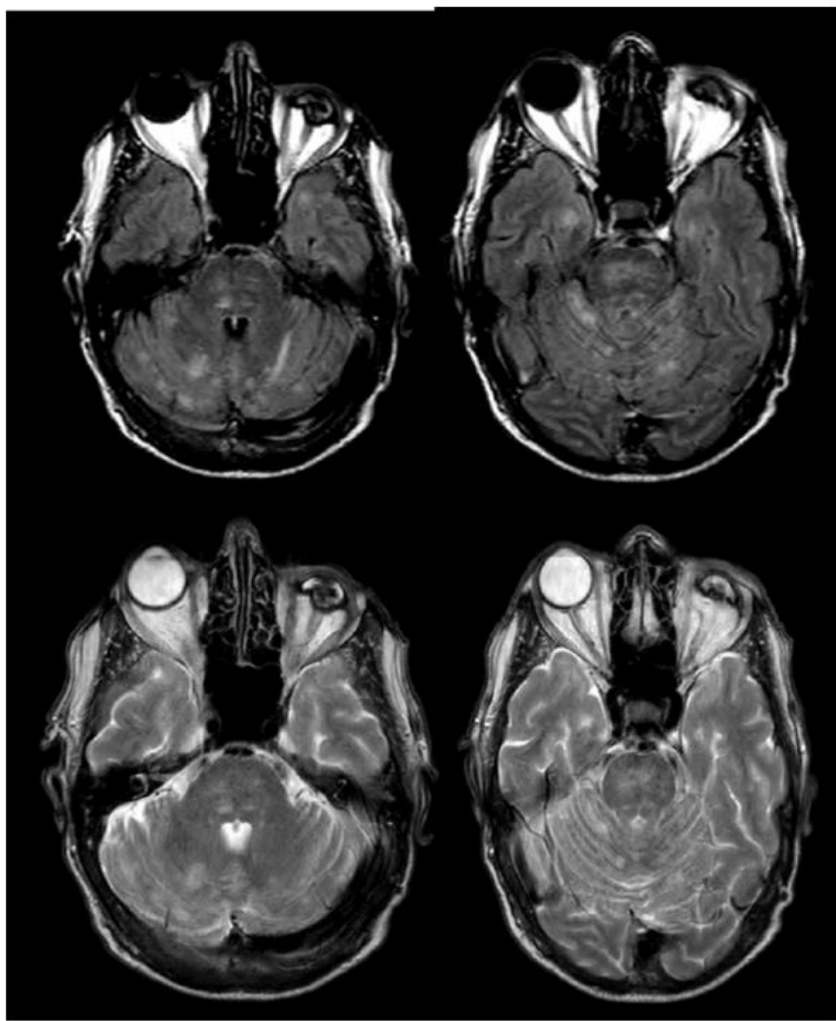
Listeria. MRI reveals patchy ill-defined T2 hyperintense lesions with peripheral contrast-enhancement and with hyperintensity on DWI sequences.
